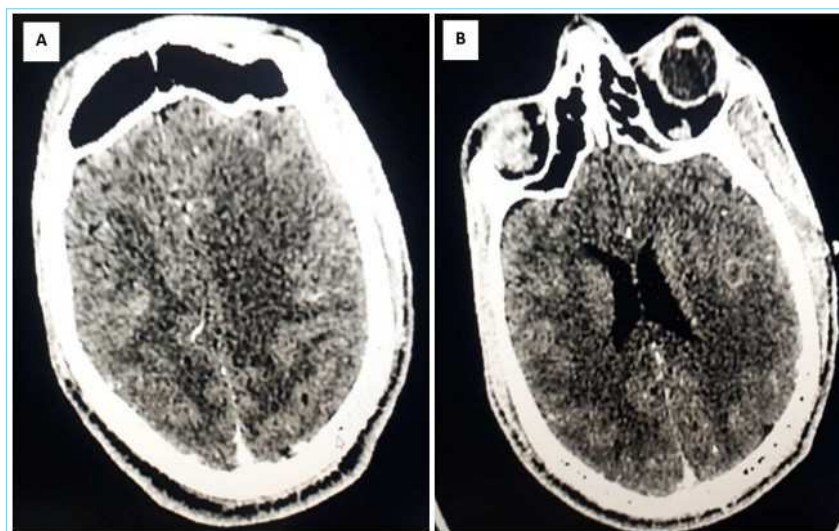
(A & B): Brain CT showing multiple hyper -dense nodules with central dots in the cerebrum at the grey-white matter junction.
